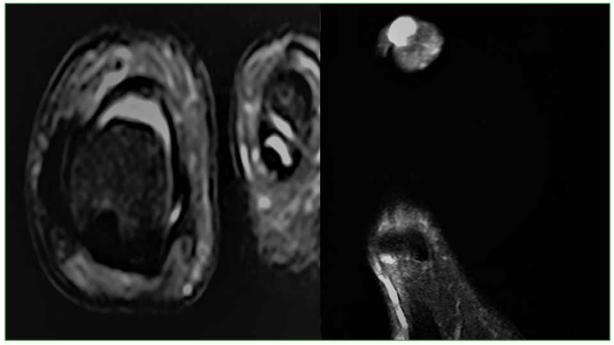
MRI, coronal and sagittal slices. No bone involvement is observed. Right: hyperintense image in the distal region of the toe, compatible with hemangioma
